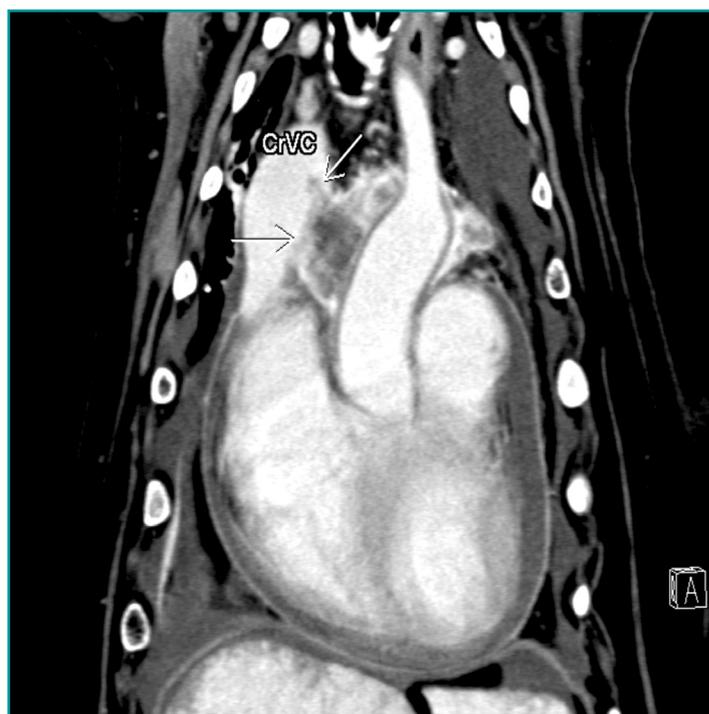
Chemodectoma with invasion of the vena cava (CT: coronal scan).
